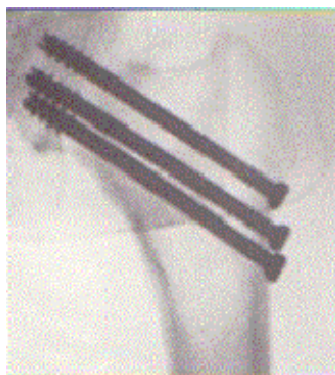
X-ray showing implanted cannulated lag screws.
